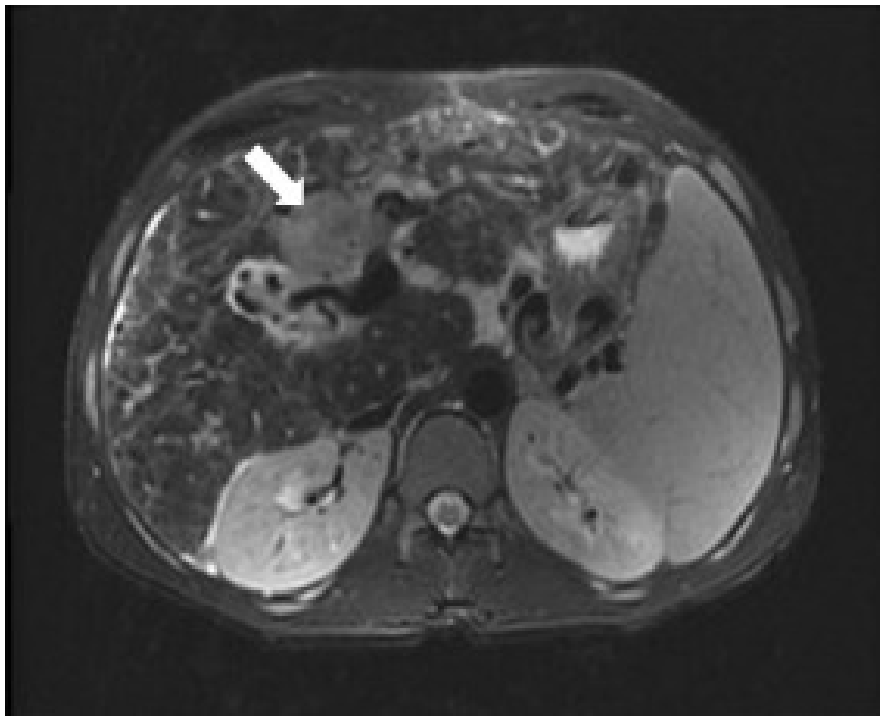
A gadolinium-enhanced MRI scan
